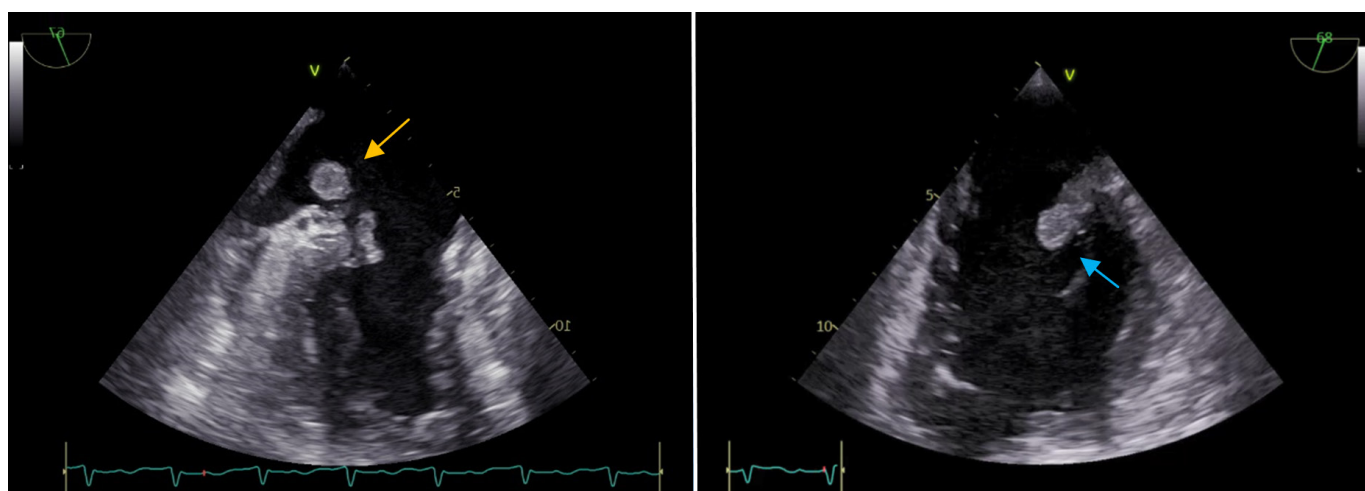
Transoesophageal echocardiography vegetation on the mitral valve with globular shape (orange arrow) and hypoechogenicity complicated with annular abscess (blue arrow).
